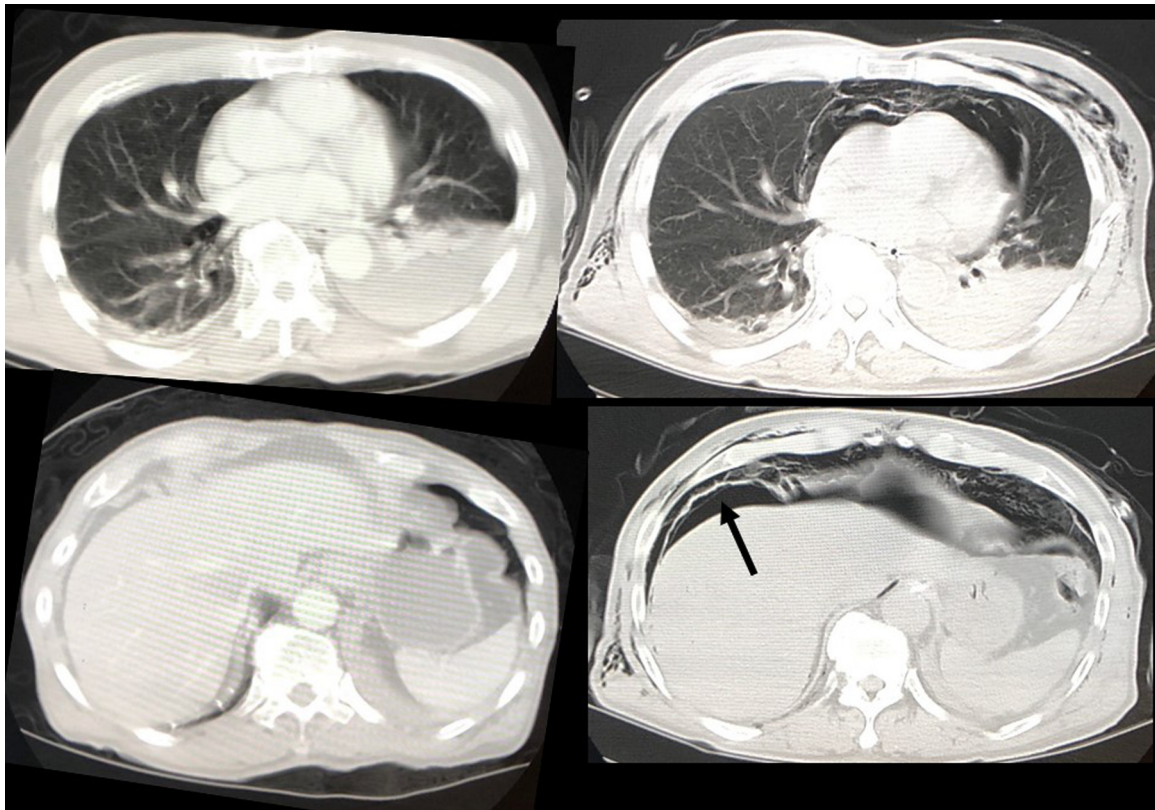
Truncal CT on arrival (left) and on the 3rd hospital day (right).
